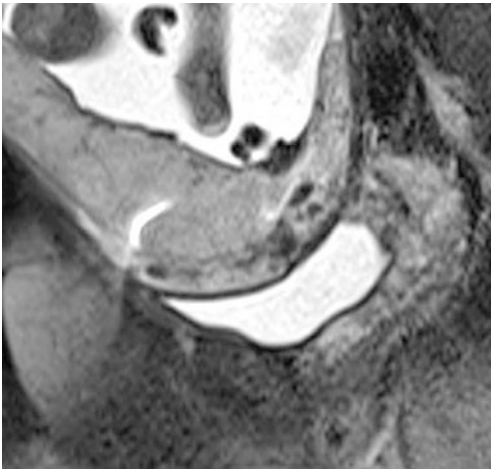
Placenta increta. T2-weighted sagittal MRI with clearly hypointense caverns. The boundary to the myometrium is only clearly recognizable at the anterior wall
